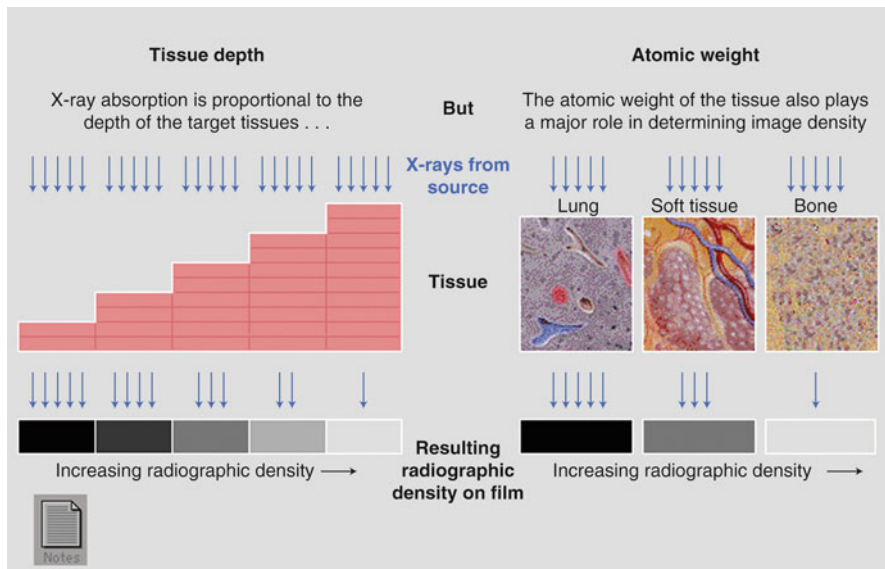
Relationship of radiographic density as a gray scale versus atomic weight (Modified with permission of Patrick Lynch, Yale University, from http://www.yale.edu/imaging/techniques/radiographic_density/index.html)
